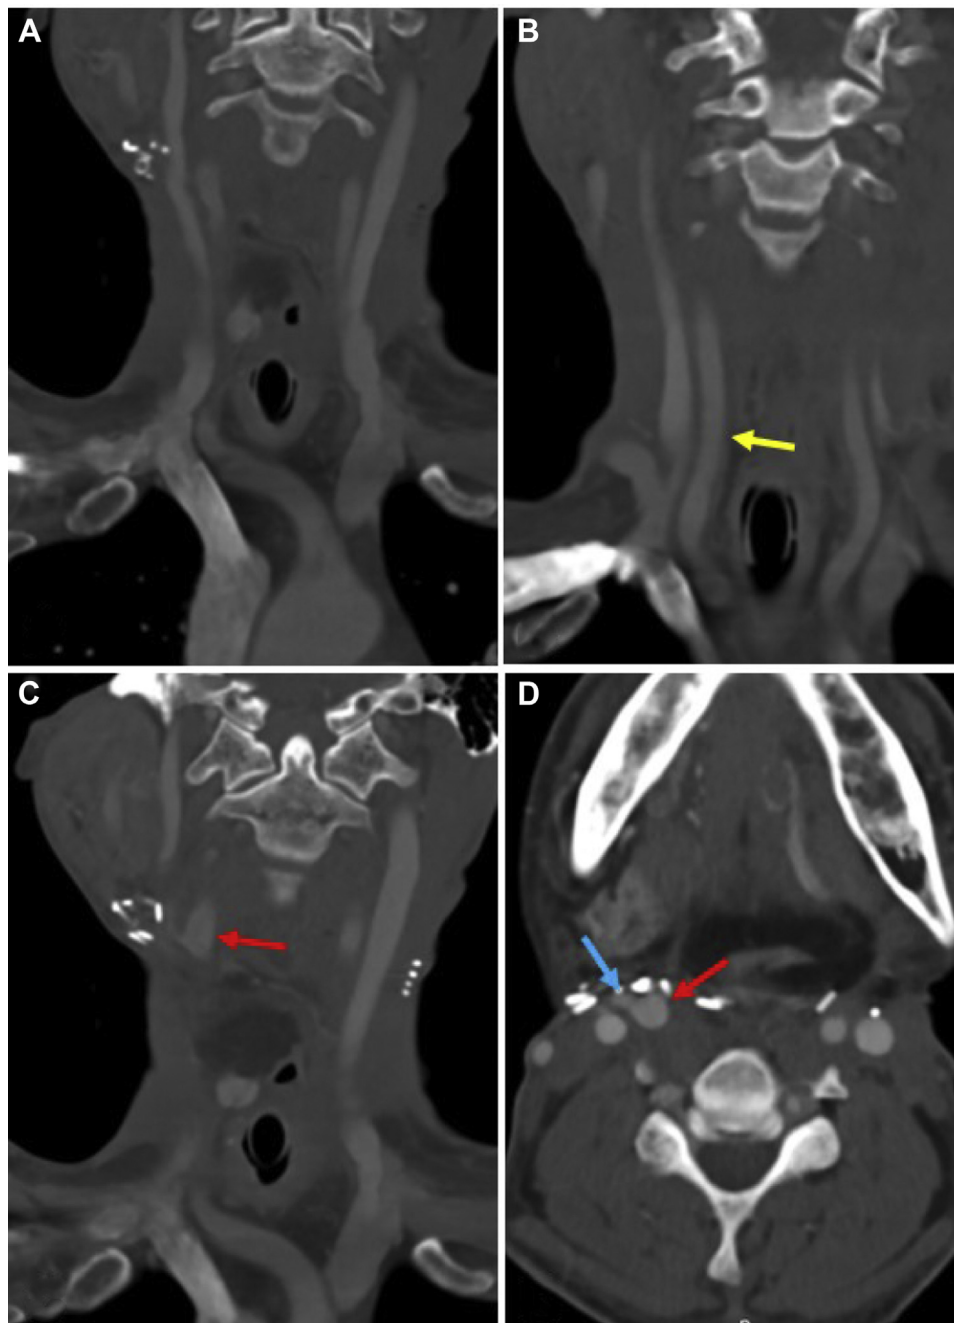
Previous computed tomography scan from an outside hospital 9 months previously, with evidence of a normal aortic arch (A) and patent carotid arterial system along the entire length (B-D), including the common carotid artery (CCA; *yellow arrow*). C and D, Patent carotid bifurcation, with right internal carotid artery (ICA) and external carotid artery indicated by *red* and *blue* arrows, respectively.
